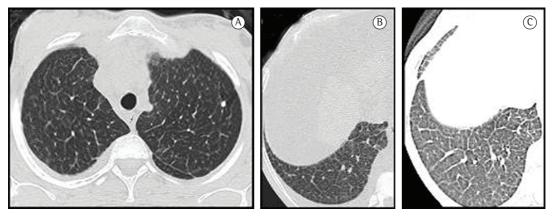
HRCT scans. In a and b, interlobular septal thickening in the bases and apices, together with right pleural effusion. In c, resolution of the pleural effusion in the right base and persistence of the interlobular septal thickening.
